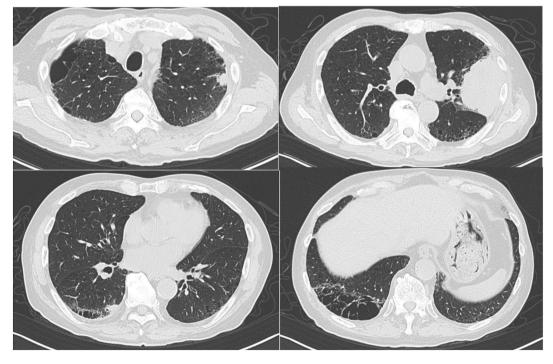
Chest computed tomography images at the start of sotorasib treatment.
